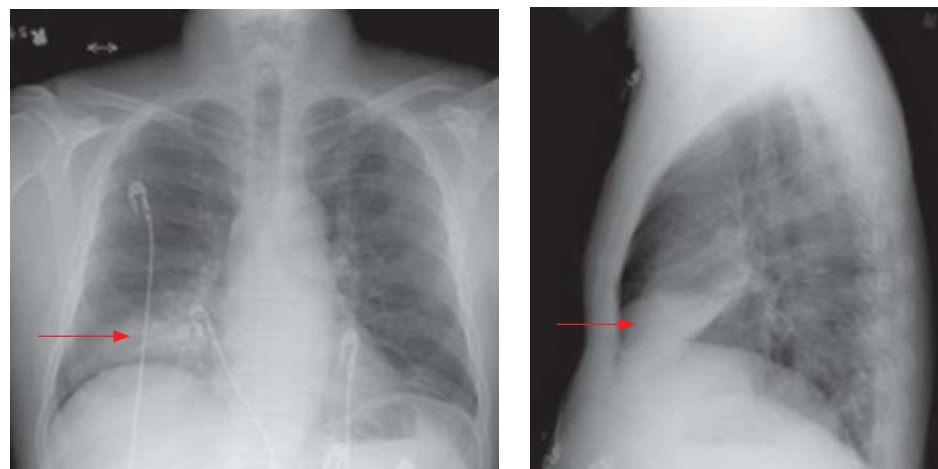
Community-acquired pneumonia. Frontal (A) and lateral (B) radiographs show airspace consolidation in the right middle lobe (red arrows) in a patient with community-acquired pneumonia. (Reproduced with permission from USMLE-Rx.com.)
